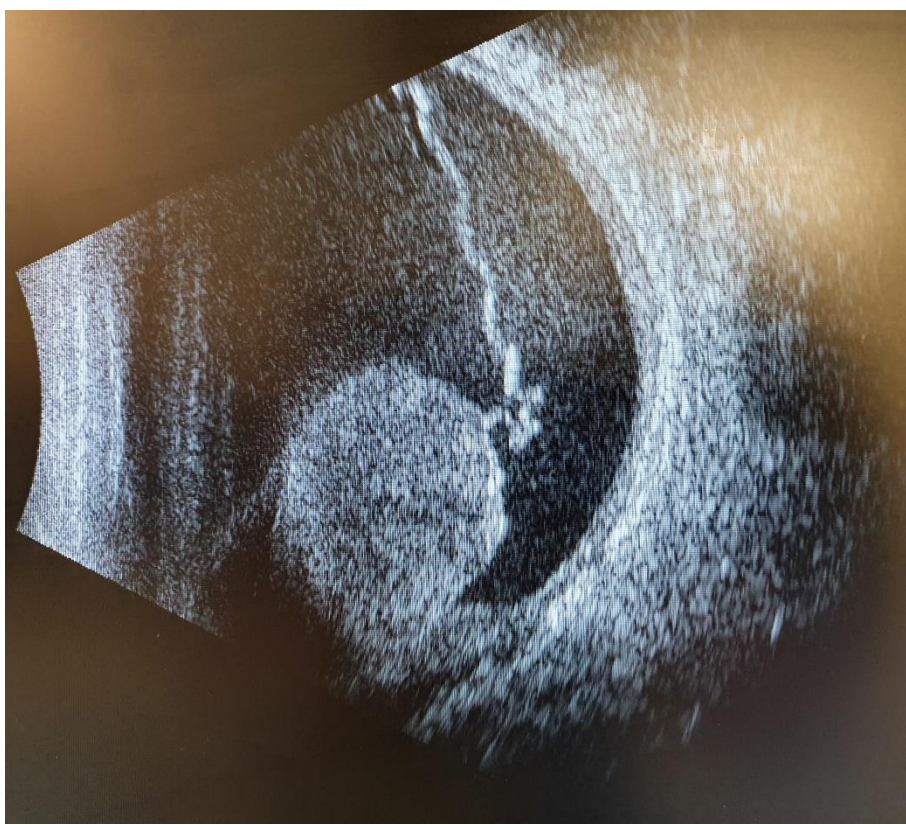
The ultrasound appearance of the underlying uveal melanoma
